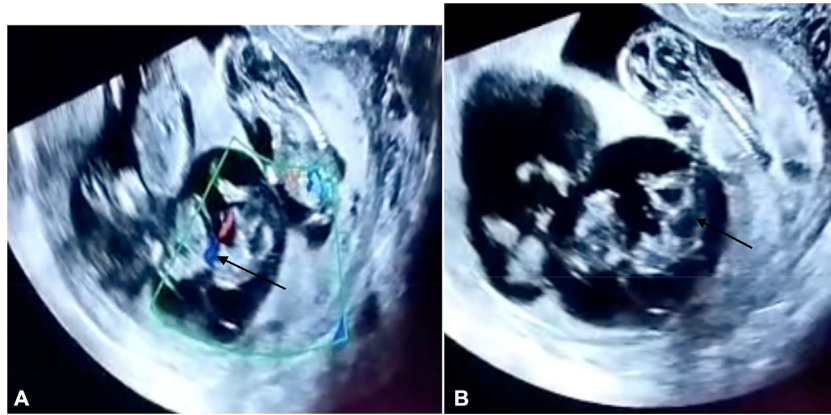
(A) Transabdominal ultrasound image showing triplet pregnancy with three separate placentae with absent cranial bone with bulging orbit giving “Frog eye appearance” (black arrow). (B) Transabdominal ultrasound image showing triplet pregnancy with normal flow in color Doppler study (black arrow).
